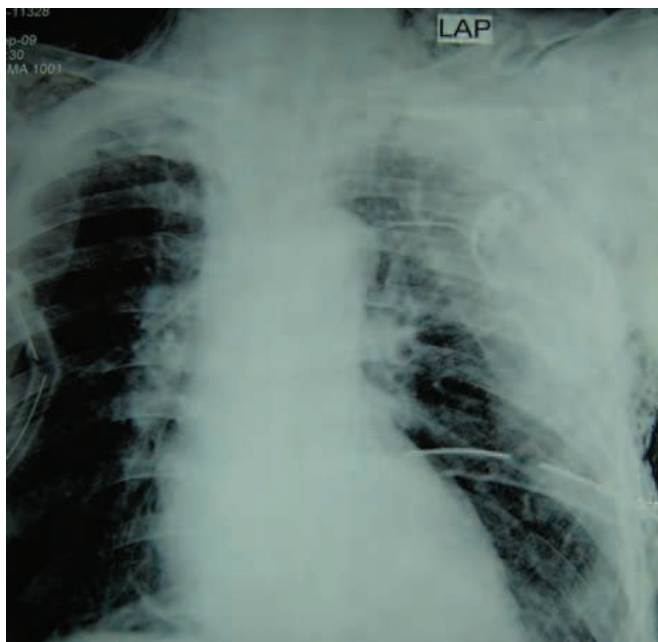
Chest roentgenogram showing subcutaneous emphysema over the chest in a patient with airway trauma
